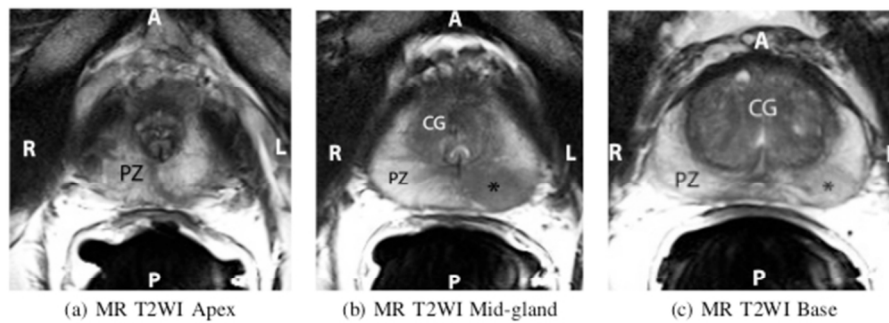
Axial T2-weighted MR images of the prostate show the apex (a), mid-gland (b), and base (c). The peripheral zone (PZ) is of higher signal intensity than the central gland (CG), the latter which is composed of the central zone and the transitional zone. The apex (a) is composed mostly of PZ glandular tissue and the urethra is seen at the level of the mid-gland as an inverted "U" (b). Note the area of hypointense signal in the peripheral zone at the mid-gland and base (asterisk, b and c), which represents a prostatic tumor. The posterior (P) aspect of the prostate is adjacent to the endorectal coil, and the right (R)-to-left (L) extent of the prostate is referred to as the lateral-to-lateral axis in the subsequent analysis.
